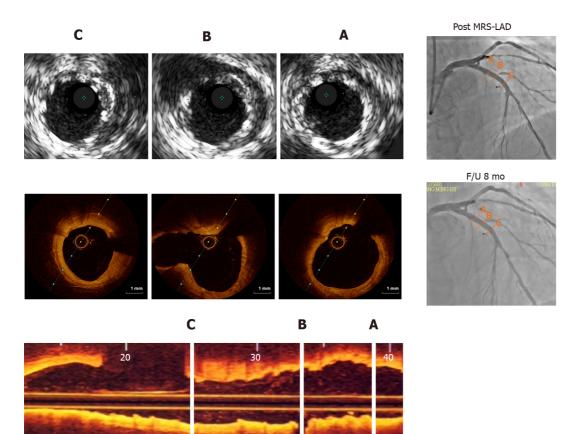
Intravascular ultrasound 8 mo prior, optical coherence tomography and coronary angiography findings. A-C: The treated segments are proximal cross-section (A), middle cross-section (B), distal cross-section (C). Post-implantation intravascular ultrasound images of the magnesium-based metal scaffolds show good apposition of struts. Real-time optical coherence tomography pullbacks vividly demonstrate almost complete resorption of the struts at the 8th month. MRS: Magnetic resonance spectroscopy; LAD: Left anterior descending artery.
